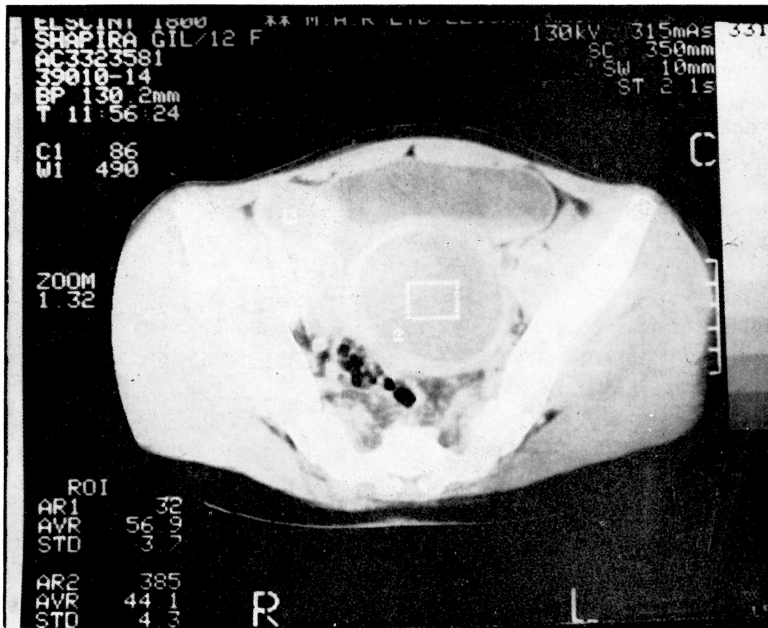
CT of pelvis disclosing two masses. The lower is the hematometra and the smaller, to the right, is the hematosalpinx.
